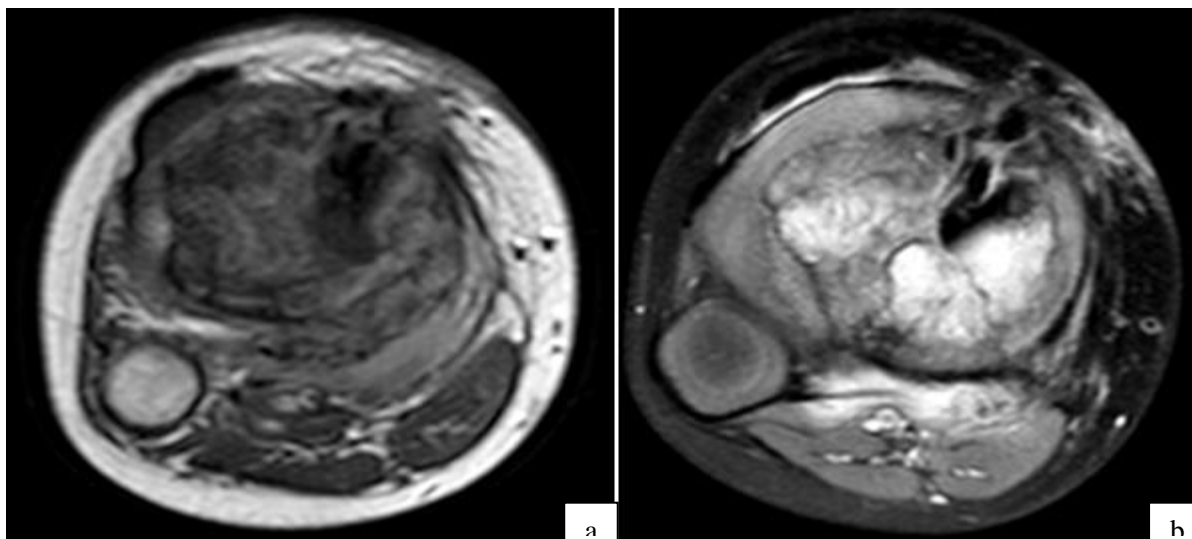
Axial section in T1-weighted sequence (a: without injection / b: after injection of Gadolinium): this process is responsible for lysis of the bone cortex, infiltrating the soft tissues and pushing back the popliteal pedicle without invading it.
